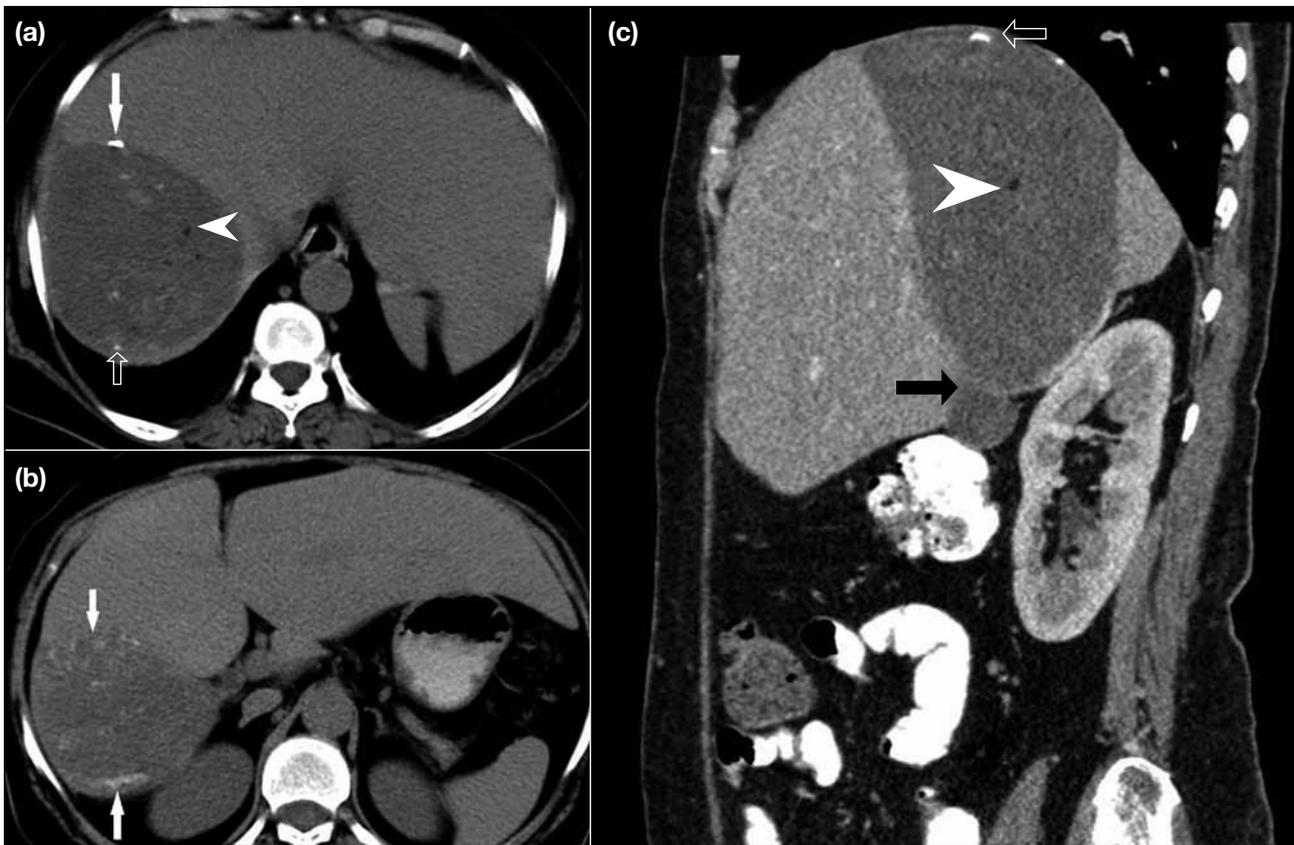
Axial non-contrast computed tomography images of case 3 showing (a) a large rounded cystic lesion in the right lobe with wall calcification (arrow), internal calcification (hollow arrow), and globules of fat density within (arrowhead); and (b) a right lobe hydatid cyst with calcifications (arrows). (c) A sagittal reformatted image shows the hydatid cyst containing fat (arrowhead), with superior wall calcification (hollow arrow) and in contact with the gall bladder (black arrow).
